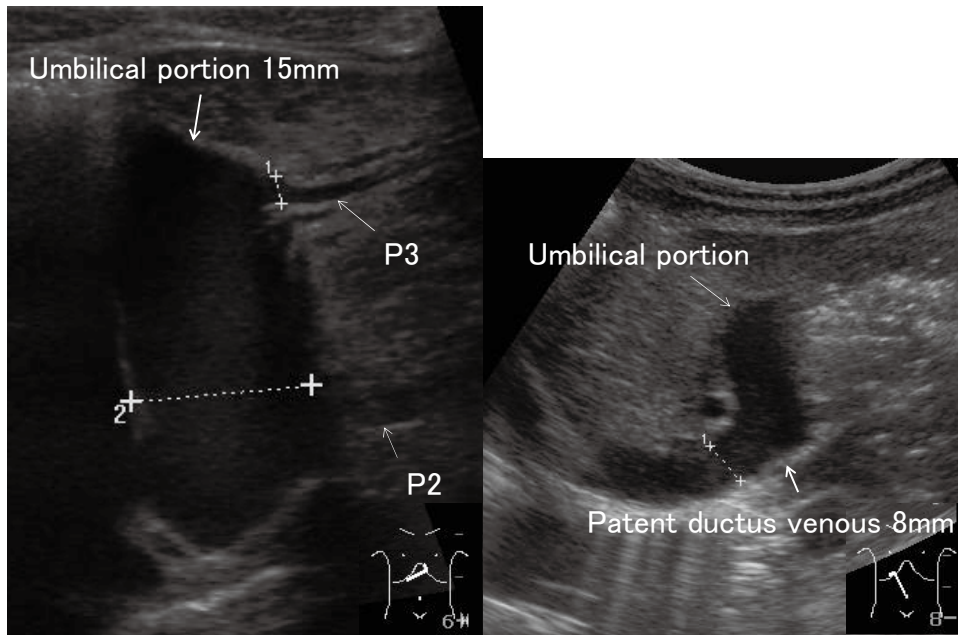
An ultrasonographic (US) image showing the ductus venosus, which is the shunt between the umbilical portion and the suprahepatic inferior vena cava (IVC).
